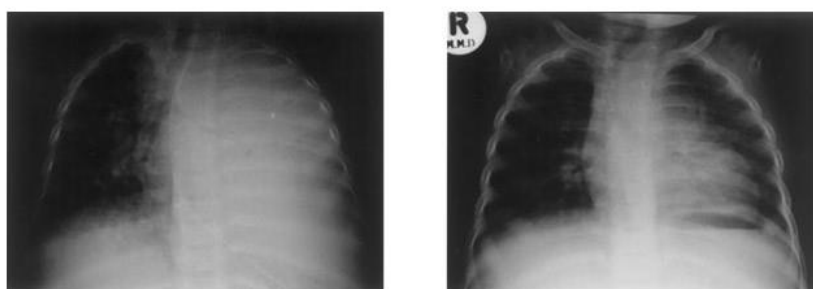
Chest radiographs showing dense opacification of left lung prior to treatment (left), and follow-up chest radiograph after 6 months of treatment (right).
